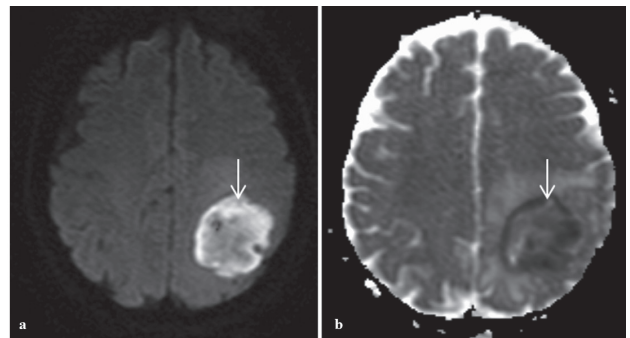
DWI and ADC map. The lesion (arrows) shows restricted diffusion.
